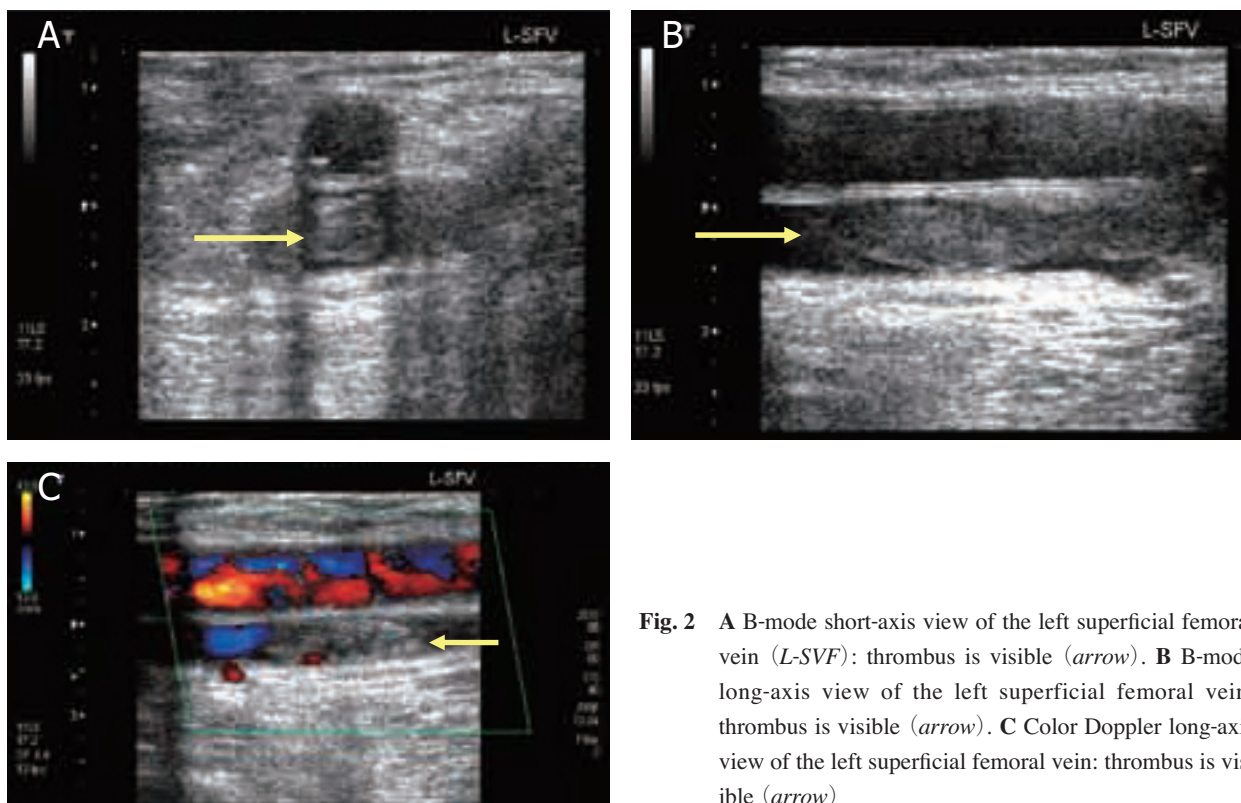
A B-mode short-axis view of the left superficial femoral vein (*L-SFV*): thrombus is visible (*arrow*). B B-mode long-axis view of the left superficial femoral vein: thrombus is visible (*arrow*). C Color Doppler long-axis view of the left superficial femoral vein: thrombus is visible (*arrow*)
